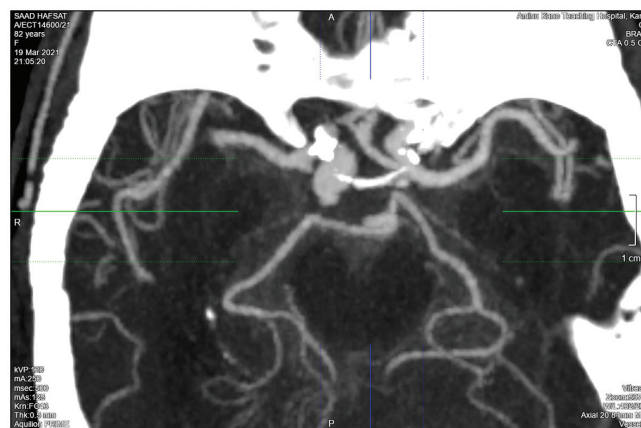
Axial view of maximum intensity projection of the cerebral CTA, showing bulbous dilation of the terminal right ICA. The apex of the aneurysm shows marginal irregularities, suggestive of a recent rupture
